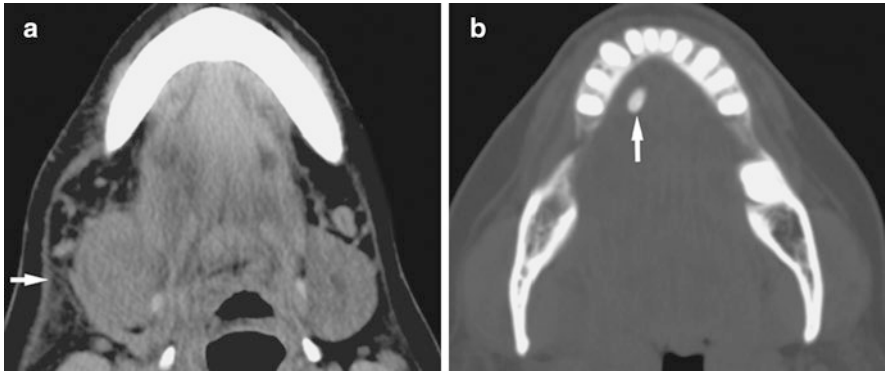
Submandibular sialoadenitis due to duct stone; 59-year-old female with right submandibular swelling. (a) Axial post-contrast CT image shows enlarged submandibular gland with stranding and reticulation of periglandular fat (arrow). (b) Axial CT image shows stone in anterior part of Wharton s duct (arrow)
